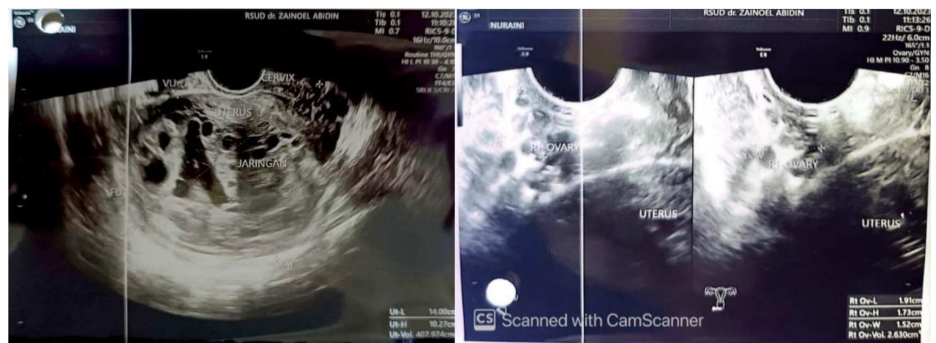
Pelvic ultrasonography showing an enlarged anteverted uterus with a heterogeneous honeycomb appearance and increased vascularity, suggestive of hydatidiform mole.
